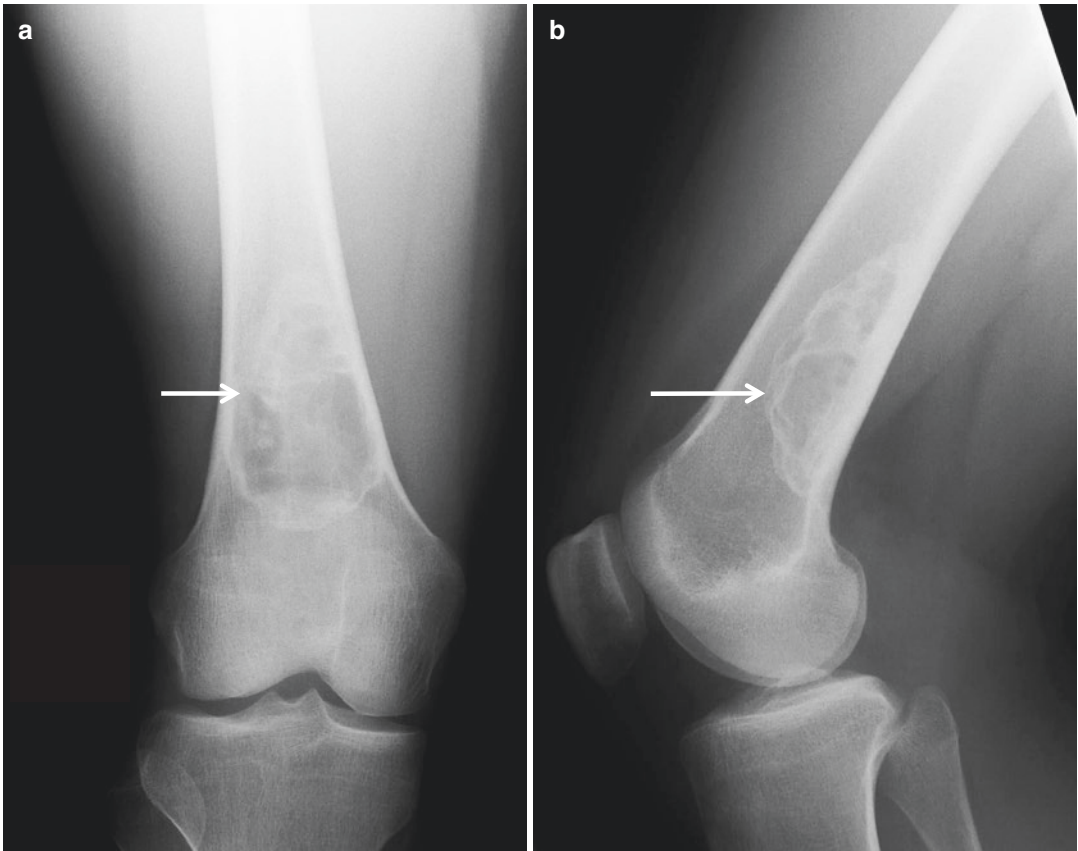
Multiple myeloma. Anteroposterior radiograph of the left femur show an intramedullary well-defined diaphyseal osteolytic lesion (*arrow*) with endosteal scalloping
